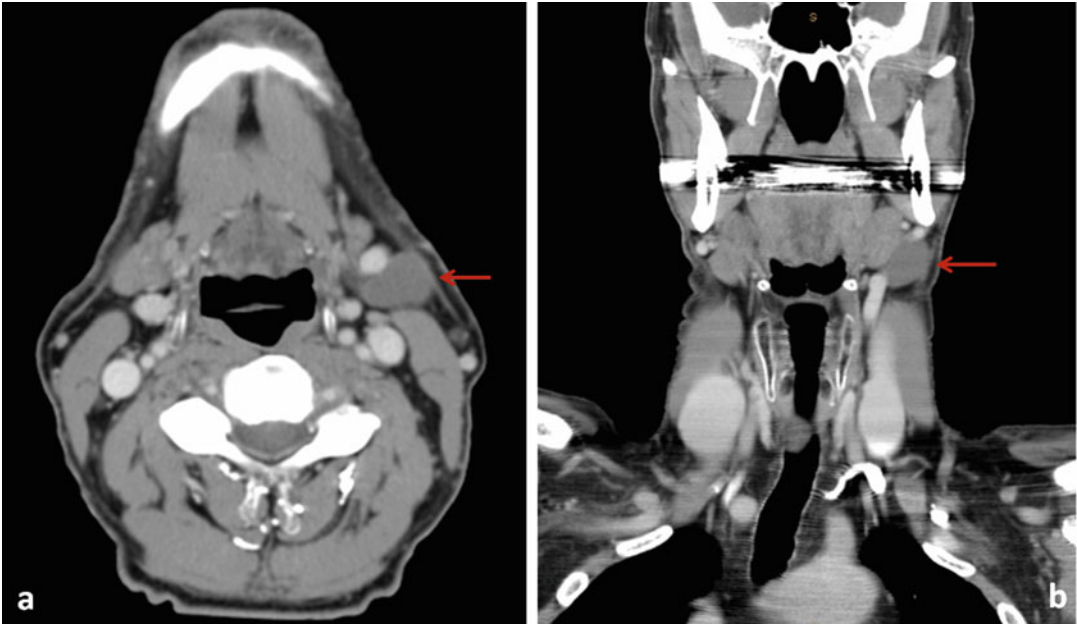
Post-contrast CT showing a second branchial cleft cyst presenting as a fluid-filled lobular mass on the lateral aspect of the left neck, posterolateral to the submandibular salivary gland, lateral to the carotid space, and anterior to
